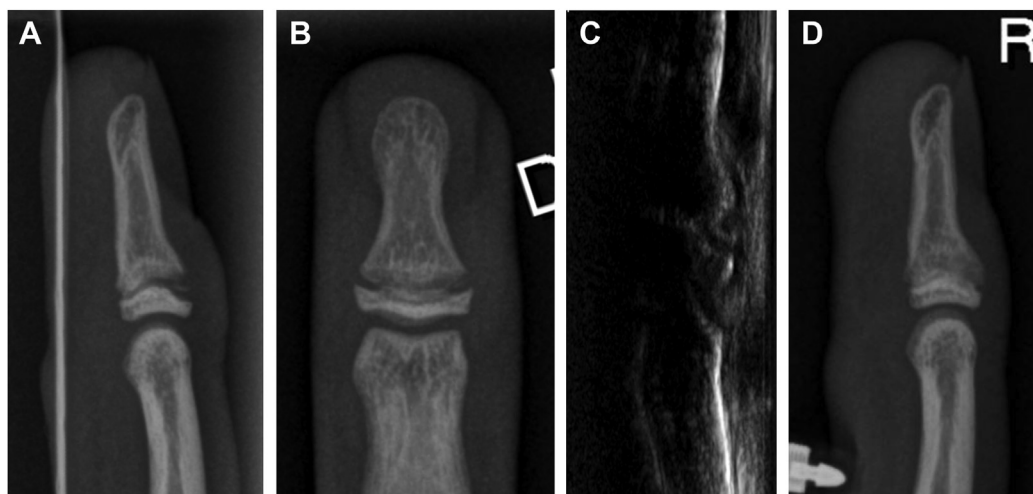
A and B, Radiographs of the distal phalanx of the right ring finger. C, Ultrasound image of the dorsal aspect of the right ring finger's distal interphalangeal joint. D, Radiographic consolidation of the right ring finger after 3 mo.
